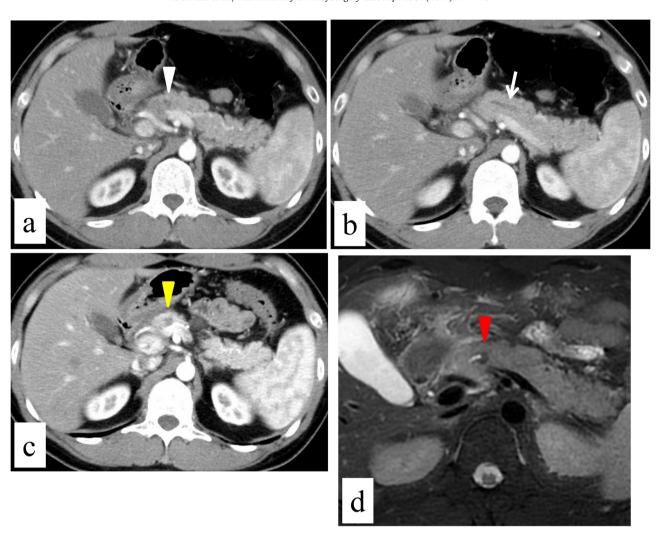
(a) Contrast-enhanced computed tomography (CT) scan showed a poorly enhanced and indistinct nodule in the pancreas body (white arrowhead). (b) The distal side of the main pancreatic duct (MPD) was dilated (white arrow). (c) The mass in the pancreas body was 10 mm in diameter 53 days later (yellow arrowhead). (d) The mass showed low signal intensity on T2-weighted images obtained by magnetic resonance imaging (MRI) (red arrowhead).
